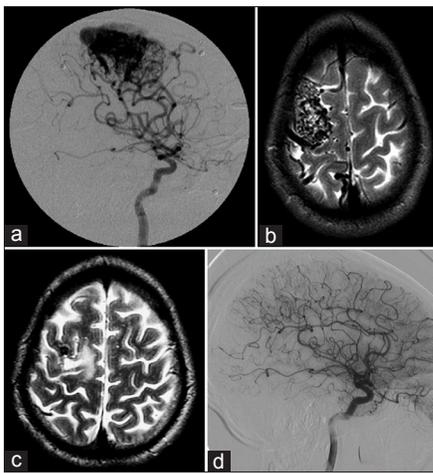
Large arteriovenous malformation (AVM) treated with two sessions of staged stereotactic radiosurgery (SRS) with transient complication in a 37-year-old male presenting with headache. (a) Digital subtraction angiogram (DSA) showing a large right frontal AVM. (b) Axial T2W MRI before SRS. Six months after the second SRS, the patient presented with several episodes of subintractable generalized seizures and post-ictal left hemiparesis managed with corticosteroids and antiepileptics, that (c) correspond to a T2W hyperintense signal. (d) DSA performed 26 months after the second SRS shows cure of the AVM. The patient is seizure-free and without any neurological sequelae
